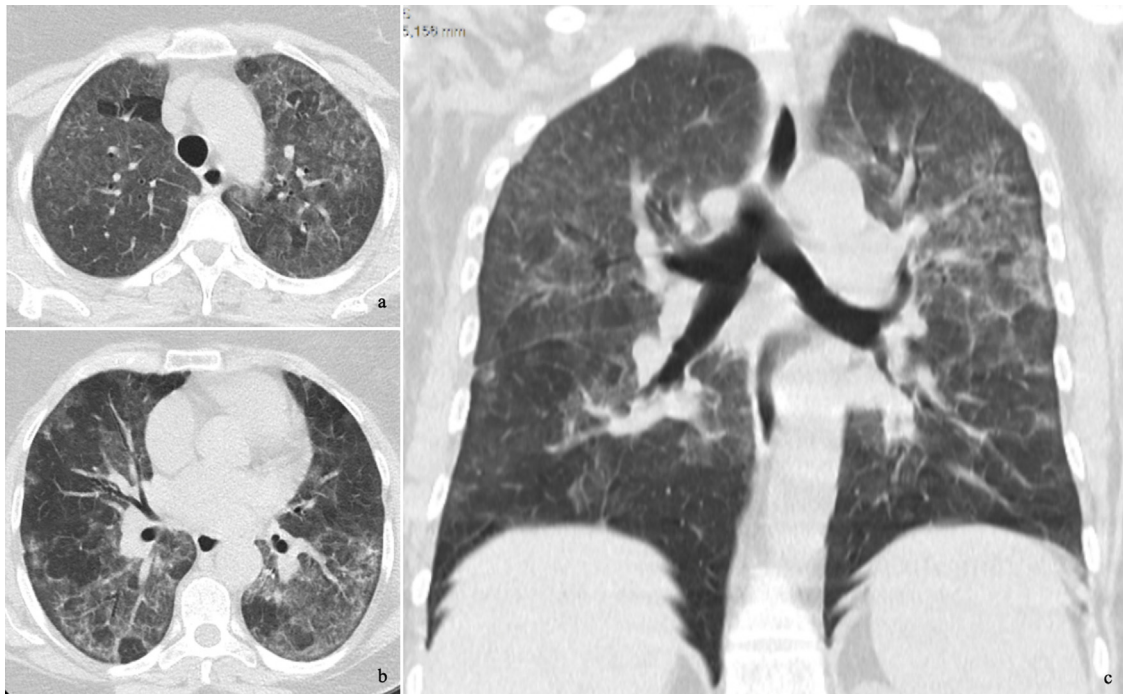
Chest CT axial (a, b) and coronal (c) images demonstrating diffuse bilateral ground-glass opacities with lobular spared areas (mosaic attenuation pattern), ill-defined centrilobular ground-glass nodules in the upper lobes and mild interlobula.
